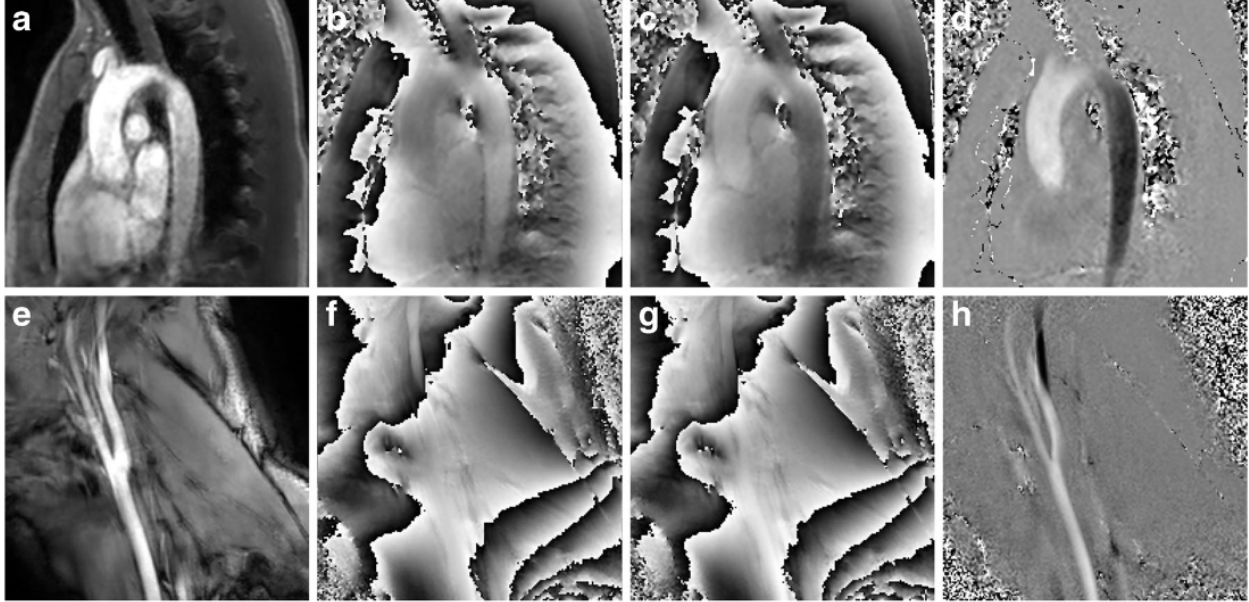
Correction of Phase Offsets in 4D Flow MRI: (a, e) Acquired magnitude images; (b, c, f, g) Phase offset errors due to tissue motion; (d, h) Phase difference images obtained after subtracting consecutive phase images with toggled bipolar gradients, effectively canceling time-dependent artifacts while leaving magnetic field inhomogeneities and non-linear gradient fields uncorrected. [135]
